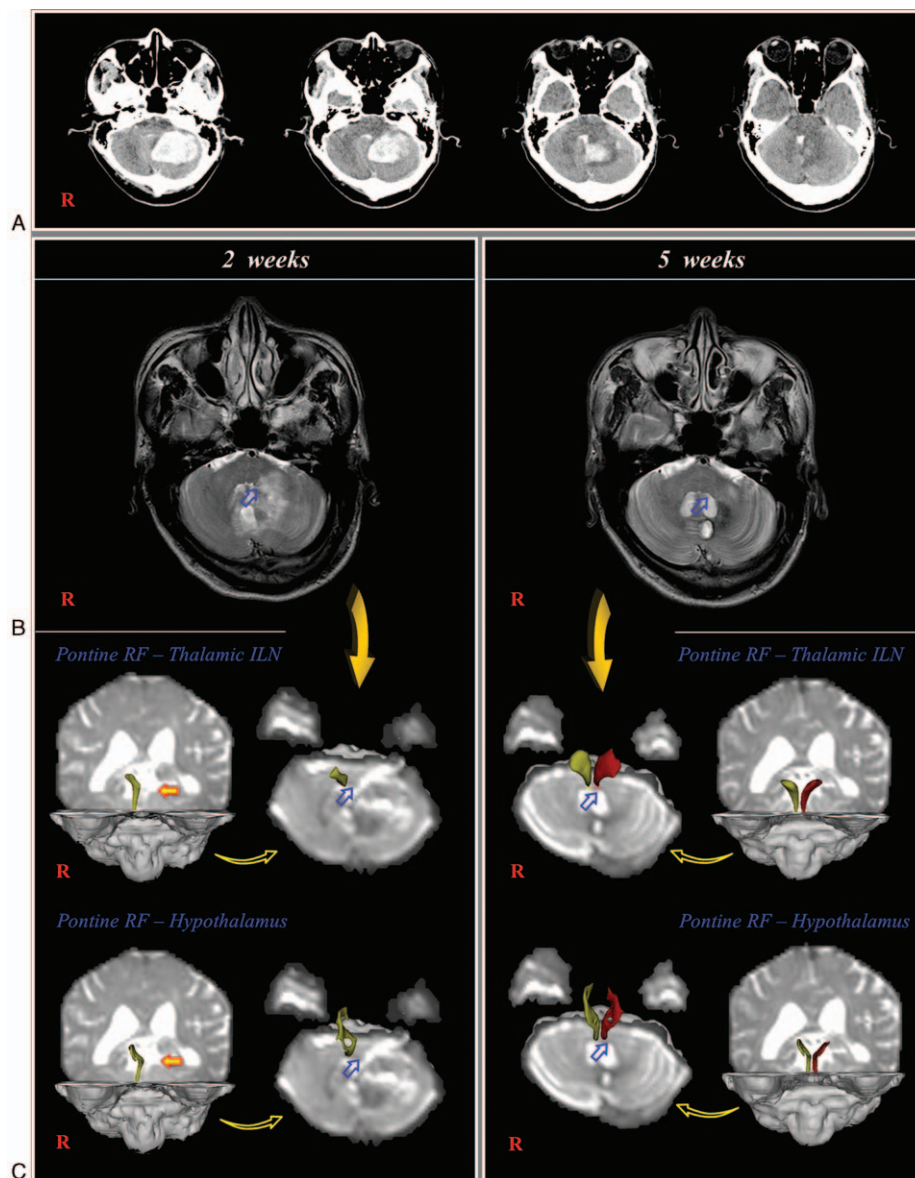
(A) Brain CT images at onset show an intracerebral hemorrhage in the left cerebellum and an intraventricular hemorrhage in the fourth ventricle. (B) Brain MRI taken at 2 weeks after onset shows a hematoma and peri-hematoma edema (blue arrow) in the left posterolateral pons and cerebellum, which are markedly resolved (blue arrow) on 5-week brain MRI. (C) Results of diffusion tensor tractography (DTT) of the patient. On 2-week DTT, neither neural tract of the left lower dorsal and ventral ascending reticular activating system is reconstructed (yellow arrows); however, these neural tracts were well-reconstructed on 5-week DTT.
